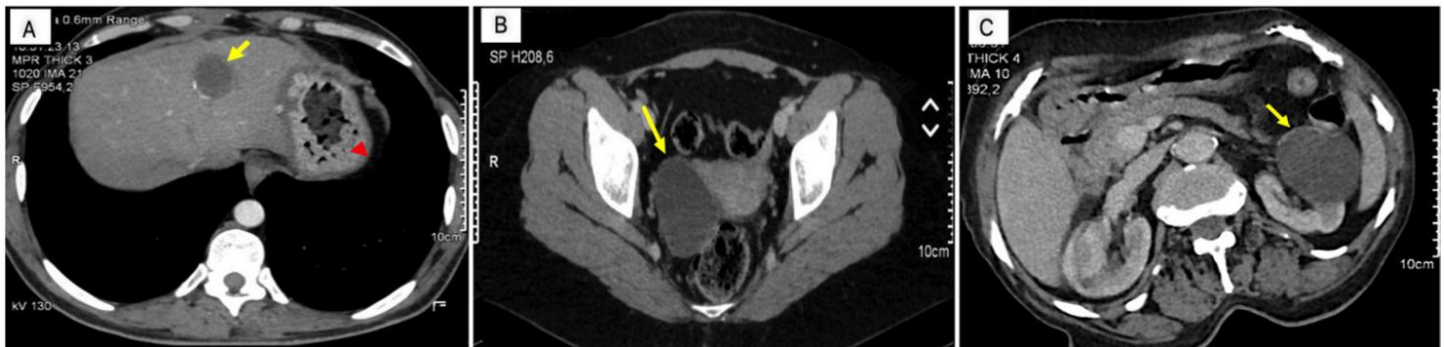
Abdominopelvic CT showing extrathoracic hydatid cysts. (A) Liver (25 × 30 mm), (B) ovary (46 × 64 mm), and (C) kidney (50 mm) cysts (yellow arrow); ovarian and renal lesions confirmed as HC. Gastric adenocarcinoma also noted (red triangle). CT, Computed Tomography; HC, Hydatid Cyst.
